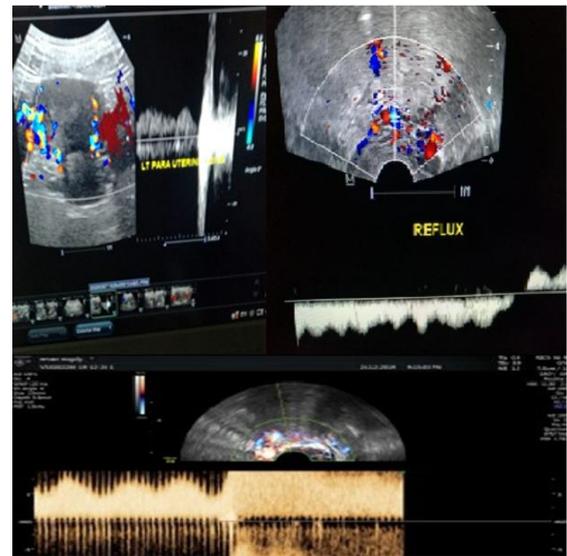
Transvaginal color Doppler showing left Para uterine vein dilatation with reflux.
